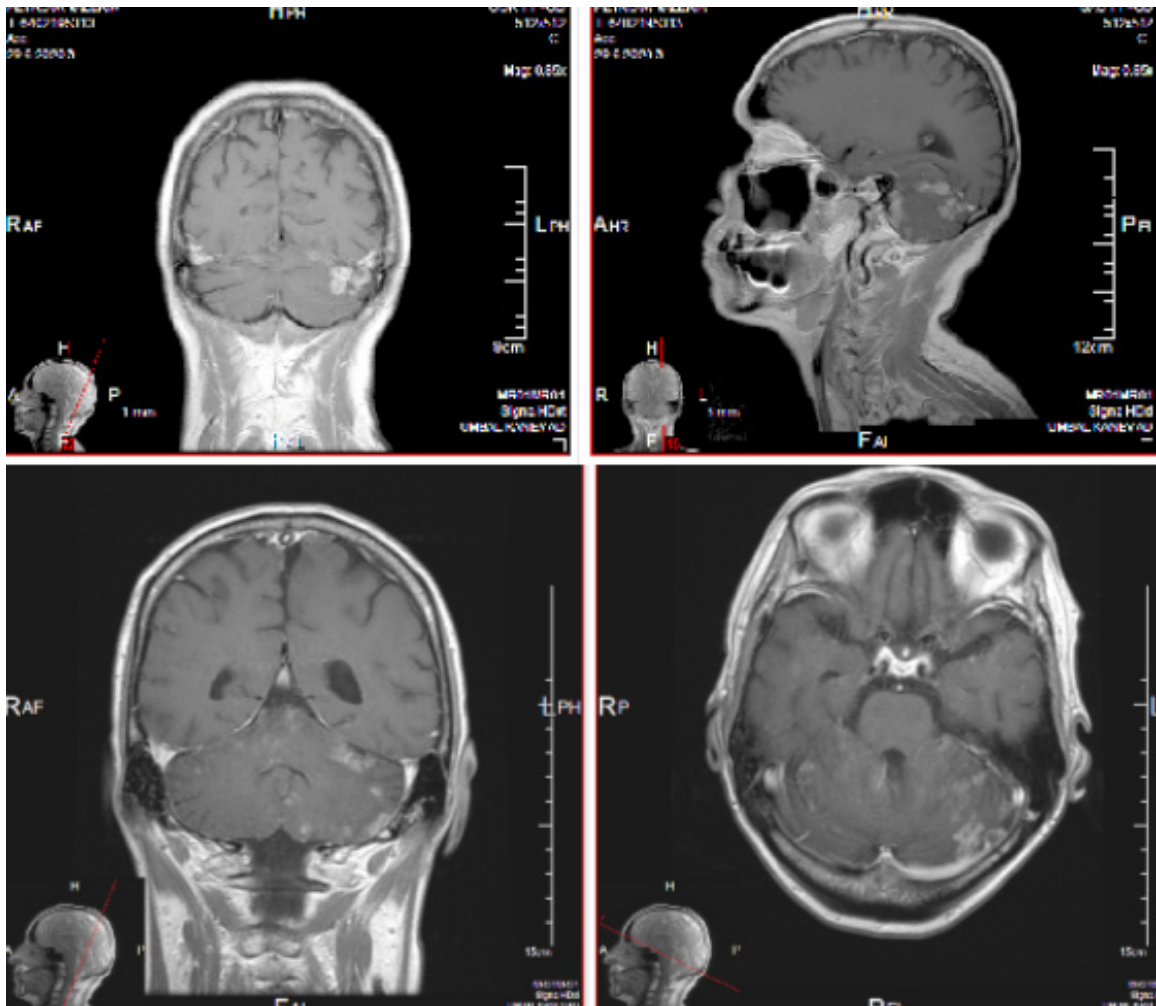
COR T1 FLAIR MRI; SAG T1 FLAIR MRI; AX T1 FLAIR MRI after 2 months of RT.
